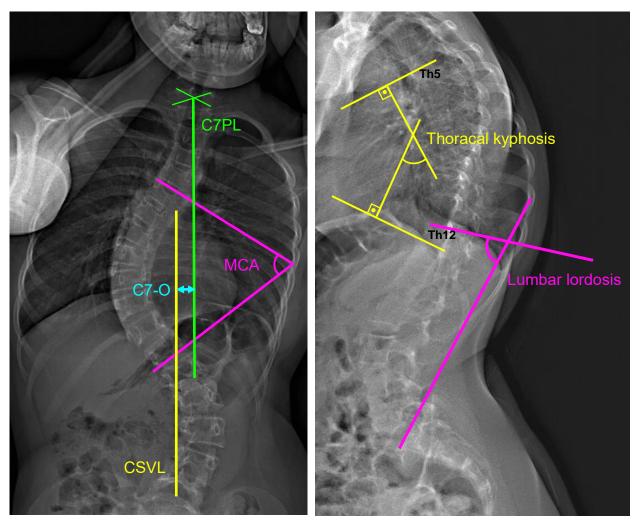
Measurement of radiographic parameters of an 11-year-old female neuromuscular scoliosis patient visualized in preoperative radiographs. The posteroanterior view (left) shows a thoracic dextroconvex curve with a major curve angle of 66 degrees and a C7-offset of 19mm. A thoracal kyphosis of 41 degrees and a lumbar lordosis of 78 degrees is measured on lateral view (right). C7PL = C7 plumb line. CSVL = Central sacral vertical line. C7-O = C7-Offset. Th12 = 12^{th} thoracal vertebra. S1 = First sacral vertebra.
